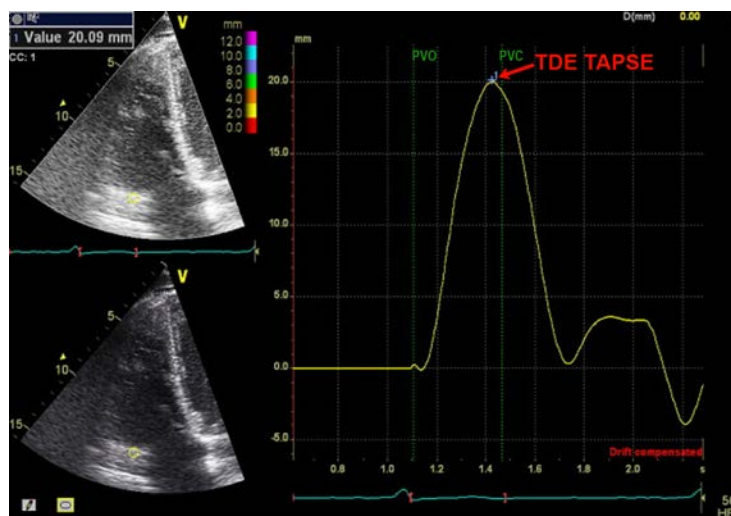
Measuring tricuspid annular peak systolic excursion using colour tissue Doppler displacement imaging (TDE TAPSE).
